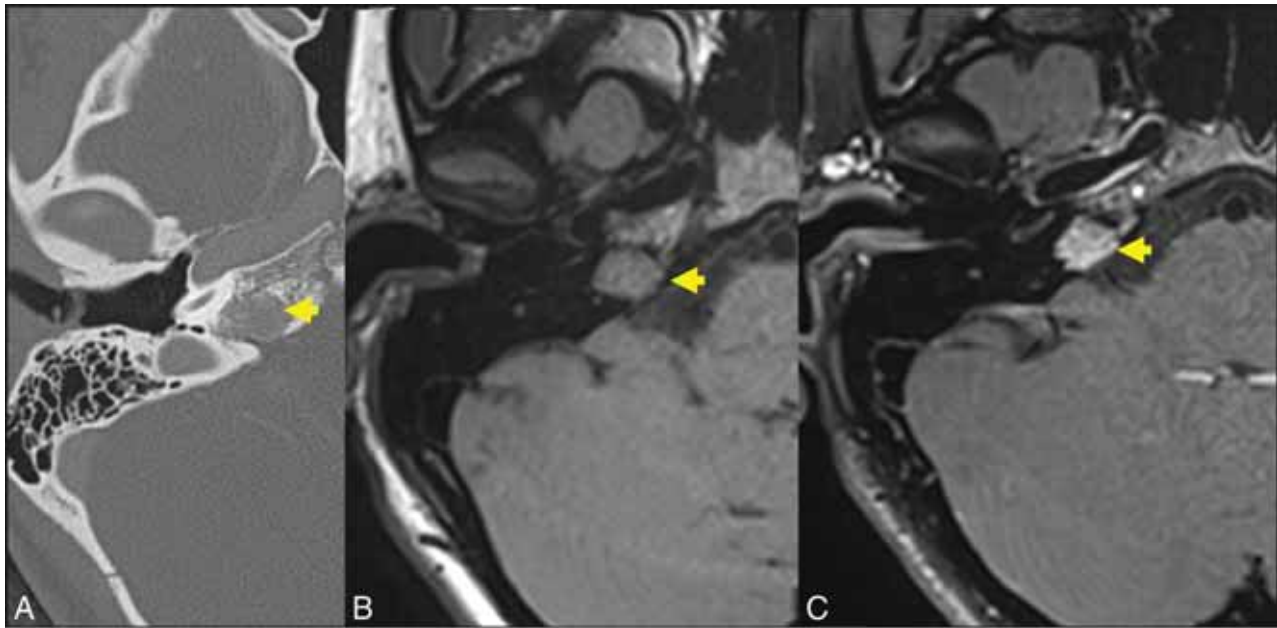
A 17-year-old girl referred for suspicion of paraganglioma identified incidentally on head CT for trauma. Axial thin-section CT (A) demonstrates a hypodense lesion centered in the right petrous apex (yellow arrow). The presence of internal trabeculae in a honeycomb pattern as well as the lesion location differentiate the correct diagnosis (IOVM of the skull base) and the suspected diagnosis of glomus jugulare paraganglioma. Axial T1 C– (B) and axial T1 C+ (C) sequences through the skull base demonstrate that the lesion is T1-intermediate (yellow arrow, B) and avidly enhancing (yellow arrow, C). A diagnosis of IOVM was made on the basis of characteristic imaging appearance. C+ indicates with contrast; C–, without contrast.
